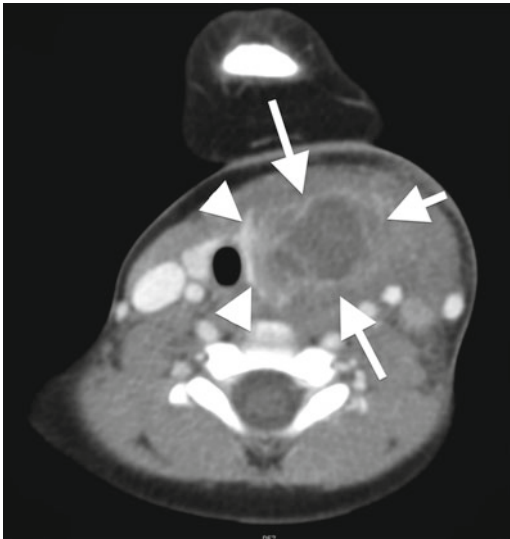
Fourth branchial apparatus anomalies. An enhanced CT in a 13-year-old with fever, neck pain, and new thyroid mass shows a “claw” of thyroid tissue (*arrowheads*) around a large, complex, peripherally enhancing fluid collection emanating from the superior pole of the left thyroid lobe, typical for an infected fourth BAA cyst.
